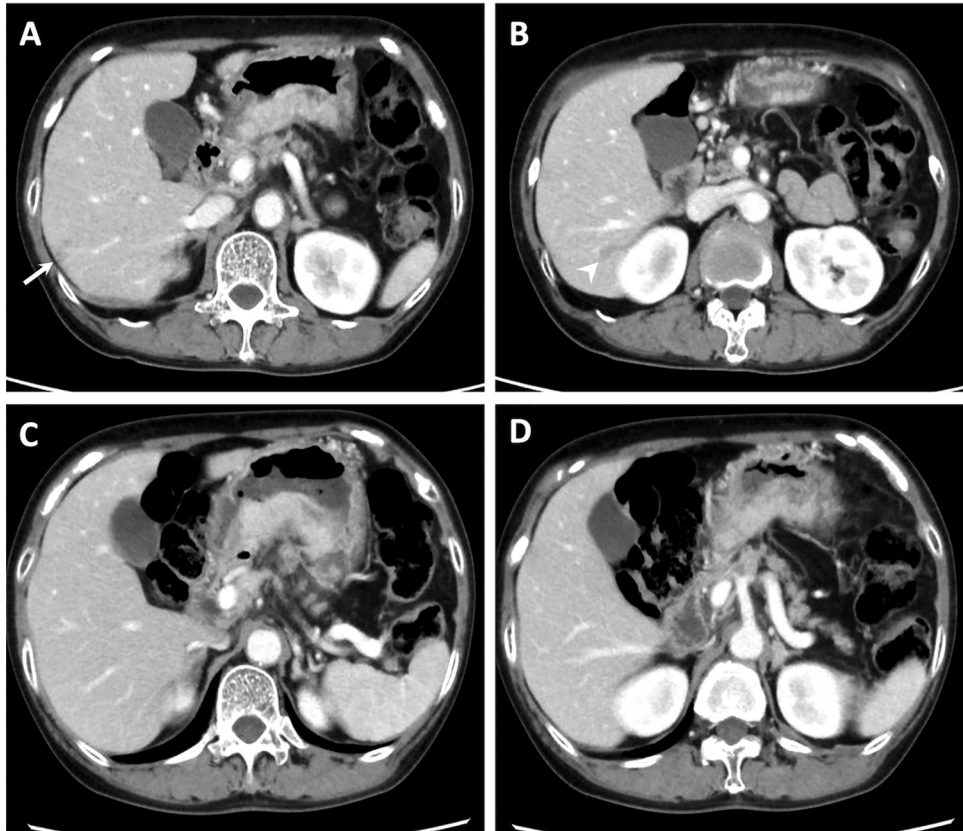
Abdominal contrast-enhanced computed tomography before (A and B) and after (C and D) systemic treatment using ramucirumab plus paclitaxel. Abdominal contrast-enhanced computed tomography before ramucirumab plus paclitaxel treatment showed liver metastases (A, arrow; B, arrowhead). After four cycles of weekly paclitaxel with ramucirumab treatment, the liver metastases completely disappeared.
